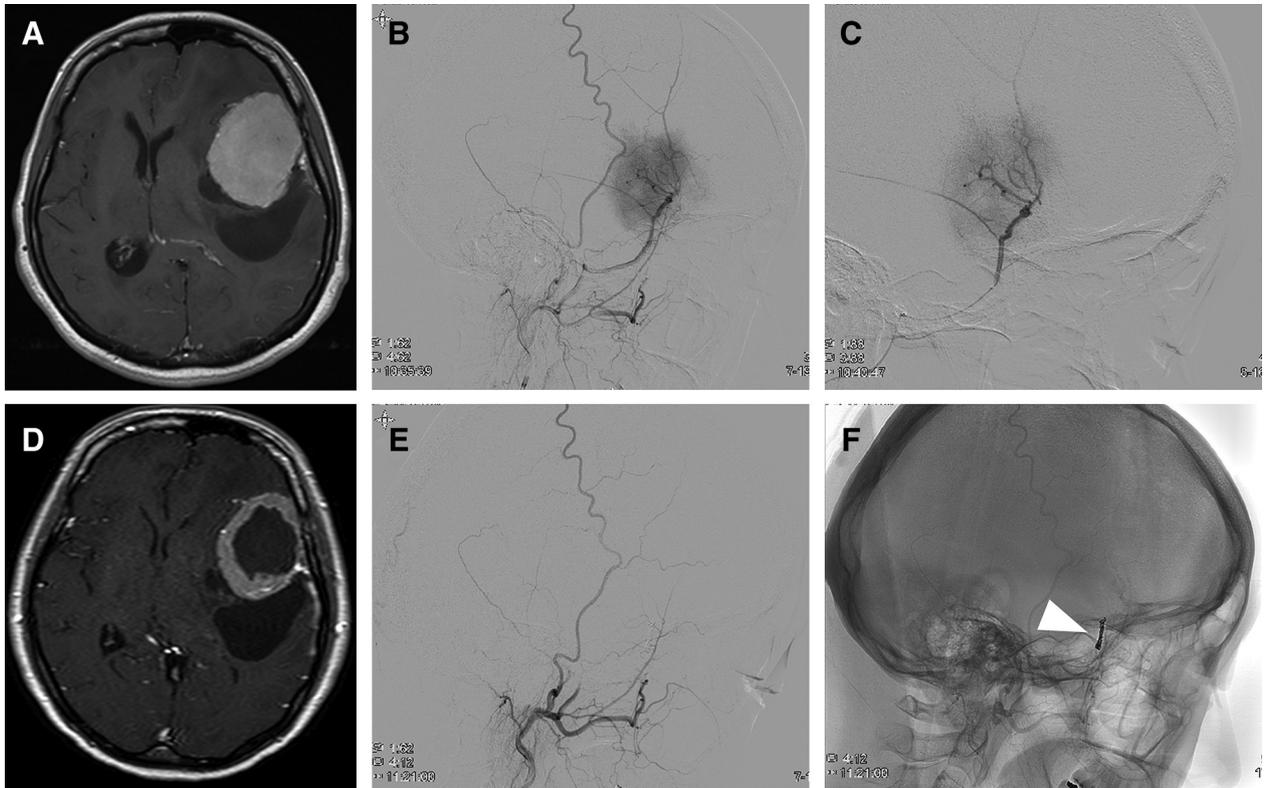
A 41-year-old woman with sphenoid ridge meningioma: (A) Pre-embolization gadolinium enhanced T1-weighted image. (B) Lateral view of left external carotid artery angiography. The sole feeding artery was middle MMA. (C) Superselective MMA angiography and embolization with Embosphere (NR was 42%). (D) Postembolization
